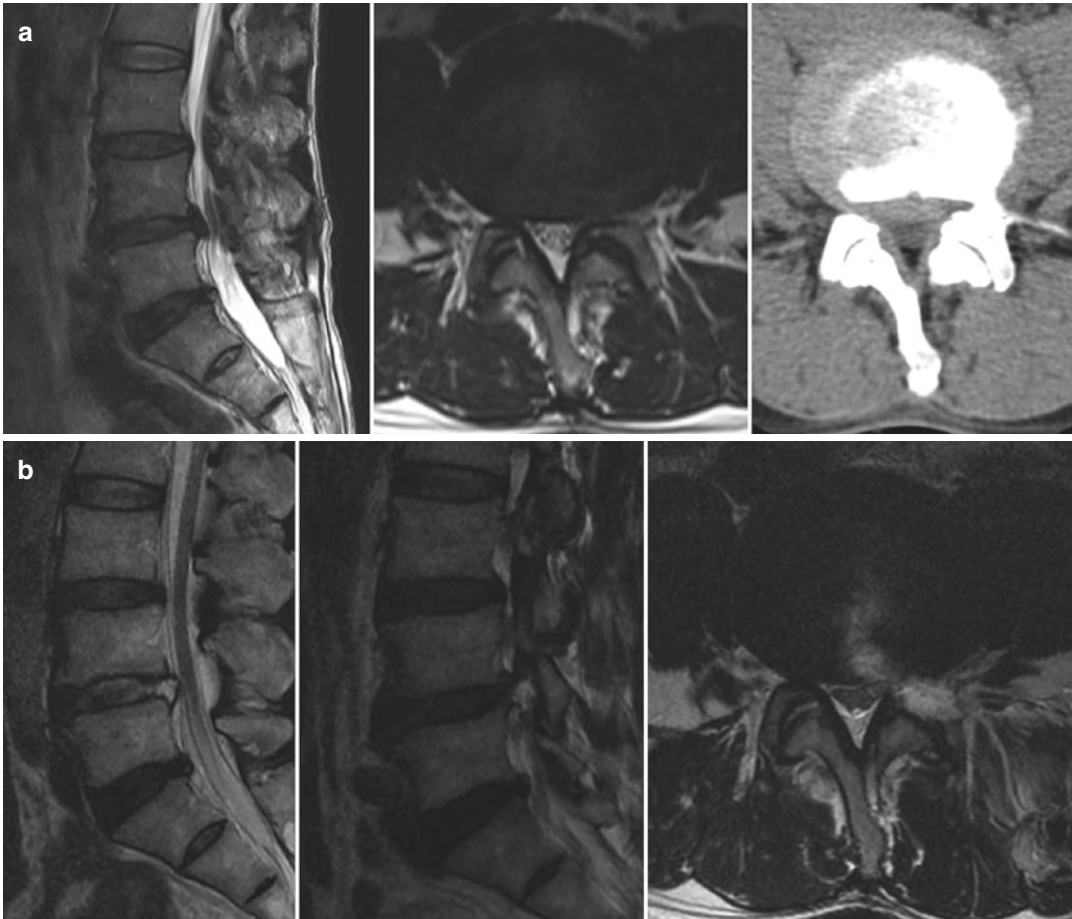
HD with lateral recess stenosis (a) MR images and CT scan showing disc herniation with lateral recess stenosis at L4–5. (b) Postop MR images showing removal of HD and the SAP
